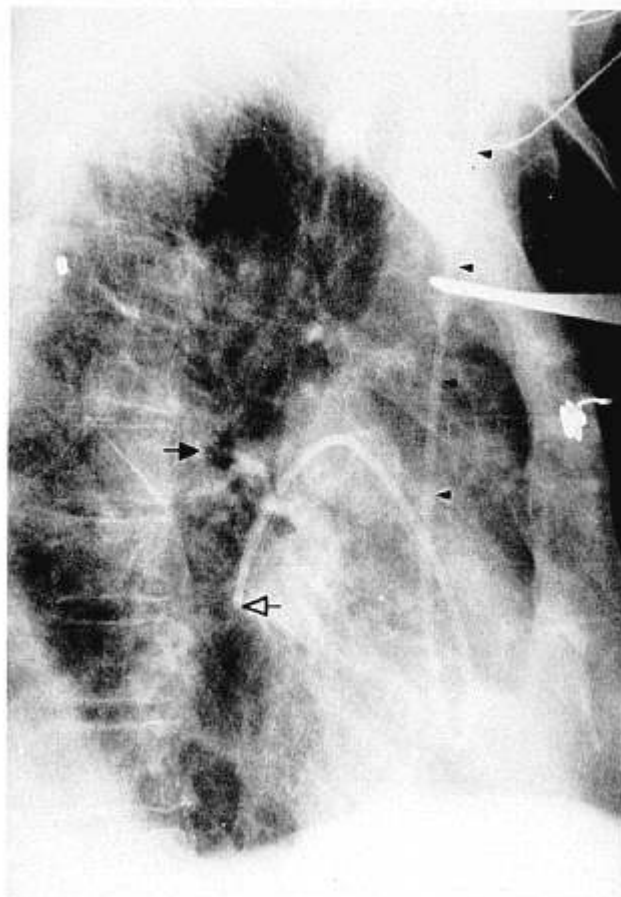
Roentgenogram of the lateral chest, showing a pulmonary catheter. The course in the superior vena cava is marked by small arrowheads (◄). The catheter tip (◄) and left mainstem bronchus (►) are also marked.
